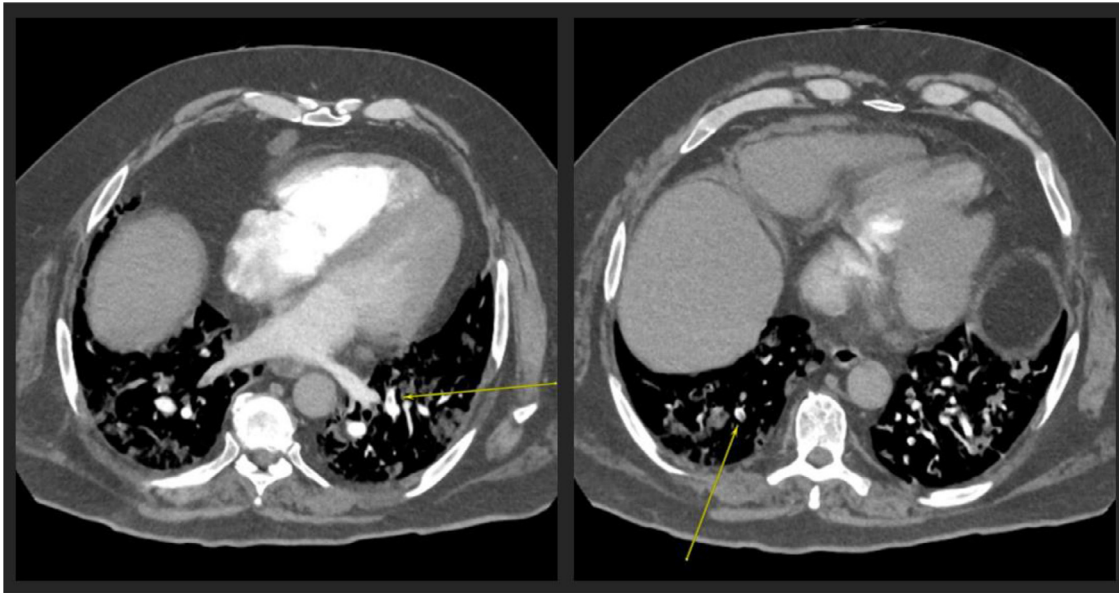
CTA Thorax demonstrating extensive patchy bilateral airspace disease consistent with COVID-19 pneumonia as well as multiple small, subsegmental PEs (yellow arrows).
